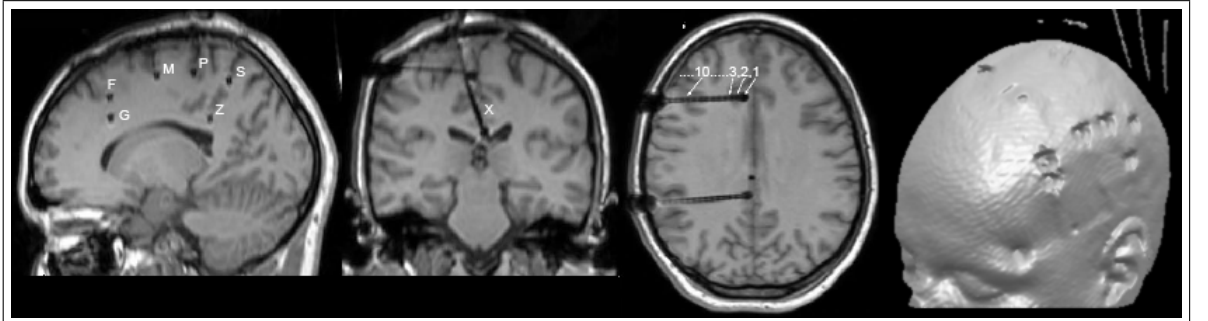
Sagittal, coronal, axial and 3D views of postoperative T1 weighted MR images. Deep electrode locations are marked on the slices (Data is obtained from Czech Republic, Brno Epilepsy Center).
